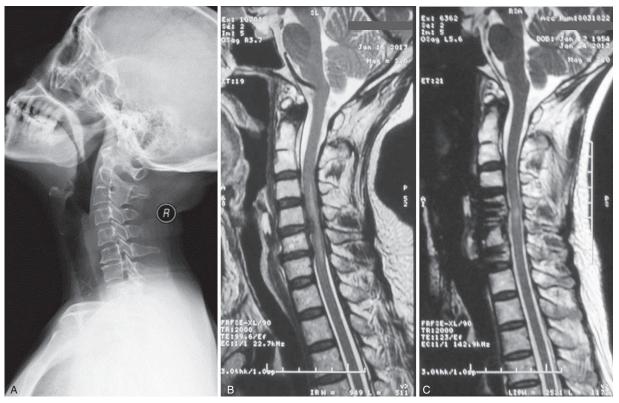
(A) Plain x-ray taken 1 month prior to surgery showing fusion of C2–C3, osteophyte formation, and decreased height of the intervertebral space at C6–C7. (B) Sagittal T2-weighted MRI performed 1 day after thyroidectomy showing herniation of C5–C6 and C6–C7 intervertebral discs causing compression of the spinal cord, and increased signal intensity of the spinal cord from C4 to C7 indicating cord injury. (C) Sagittal T2-weighted MRI 1 week after spinal surgery (C5–C6, C6–C7 discectomies, C7 subtotal corpectomy and fusion) showing excellent spinal cord decompression.
